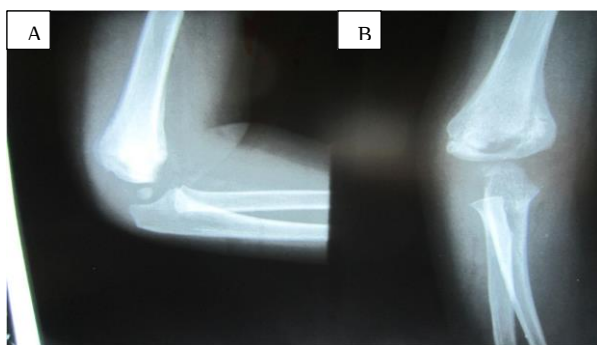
A) Lateral elbow radiograph at 18 months showing a fixed flexion posture with trochlear contour irregularity; B) Anteroposterior (AP) elbow radiograph at 18 months demonstrating varus coronal alignment with medial trochlear irregularity and preserved overall ulnohumeral congruity
